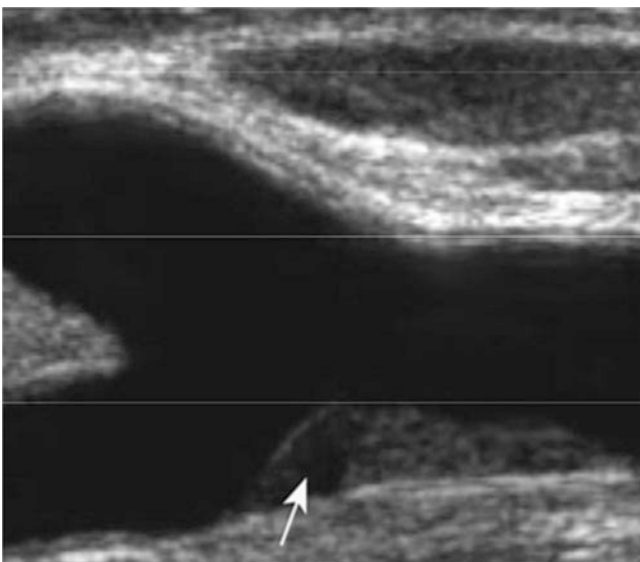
Sonographic imaging of plaques. Left: Homogeneous, well delimited, regular, smoothly bounded and moderately echogenic plaque. Right: Slightly inhomogeneous, well defined, irregular plaque with contour interruption
